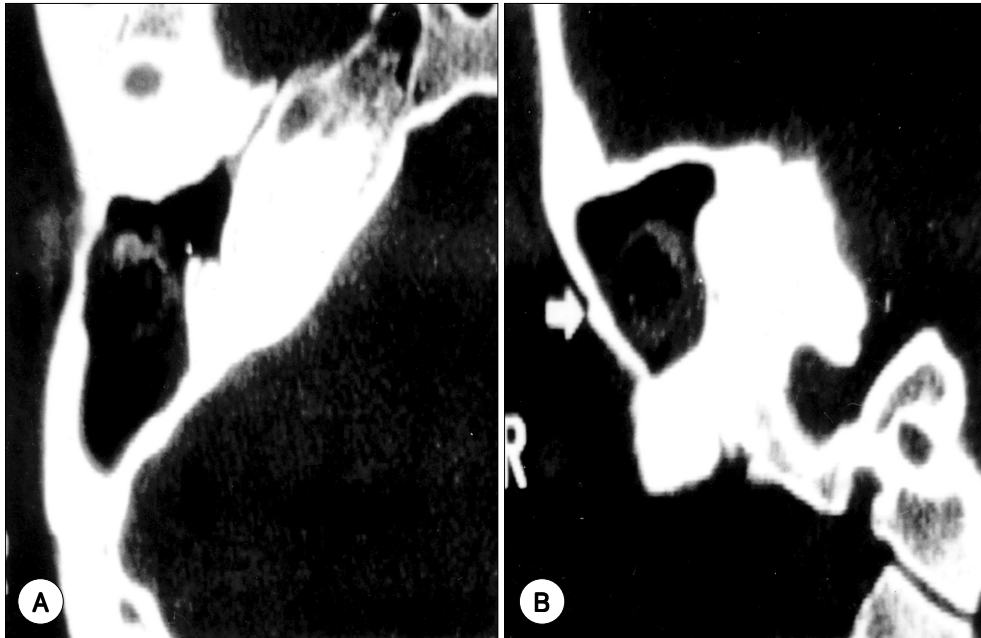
Automastoidectomy. The axial (A) and coronal (B) CT scans of right temporal bone reveal large bony defect of mastoid bone with preservation of lateral bony cortex of mastoid. Soft tissue density is seen in mastoid cavity. Henle's spine (white arrow) is preserved (B).
